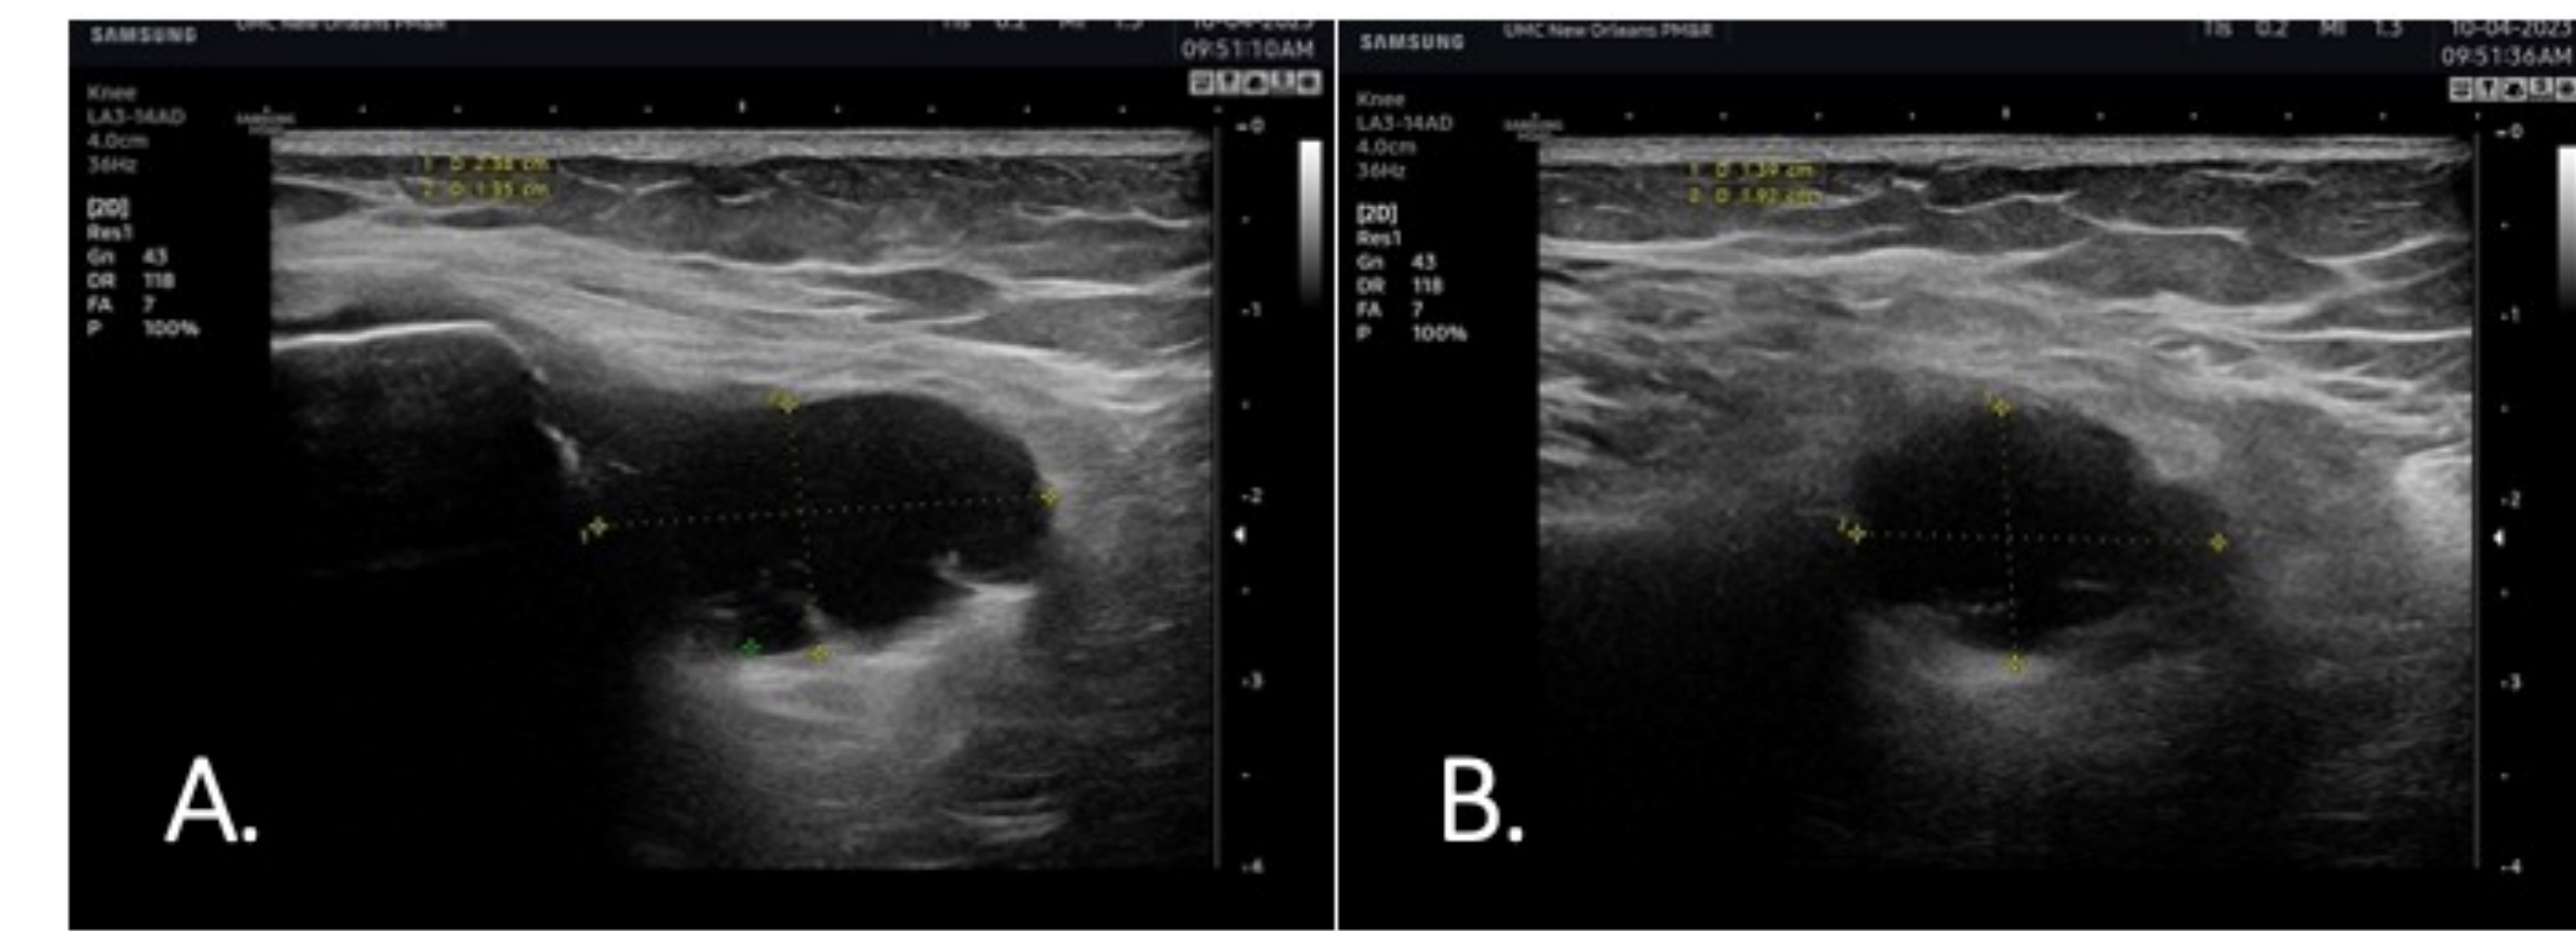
Ultrasound of the left knee demonstrating the ganglion and its close proximity to the femoral condyle. A. Long axis view of the ganglion cyst measuring 2.38x1.35 cm. B. Short axis view of the ganglion cyst measuring 1.39x1.92 cm."
